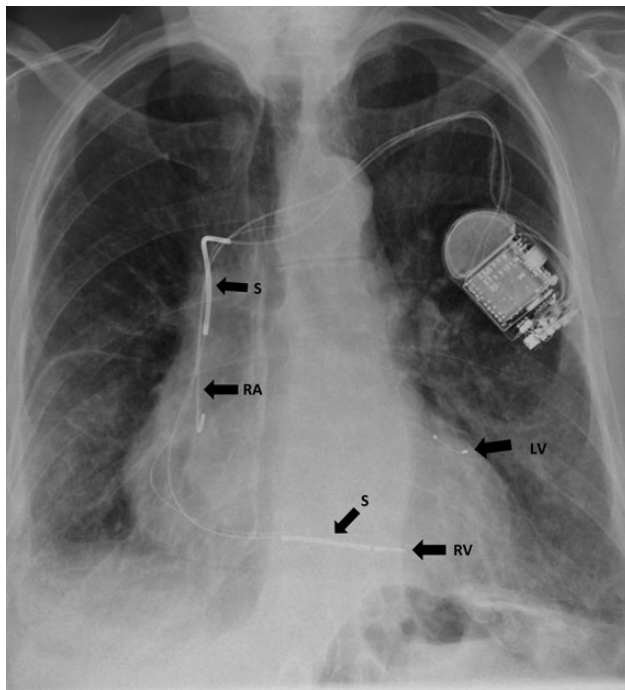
A chest radiograph demonstrating a CRT-D device—note the widened shock coils (S) located on the right ventricular (RV) lead, in contrast to the right atrial (RA) lead and the narrow left ventricular (LV) pacing lead.
